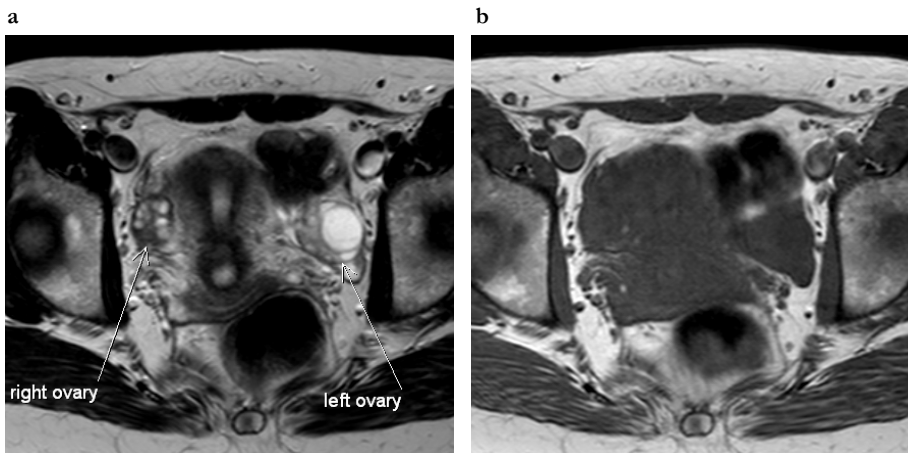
T2-weighted TSE (a) and T1-weighted TSE (b) MRI acquisitions in the transaxial plane of the pelvis, with normal ovaries at each side of the uterus in a healthy ovulating woman. The fluid-filled antral follicles have high signal on the T2- and low signal on the T1-weighted image. The dominant follicle in the left ovary is close to 2 cm in size. The ovarian stroma is slightly high in signal on the T2- and intermediate in signal on the T1-weighted image.
